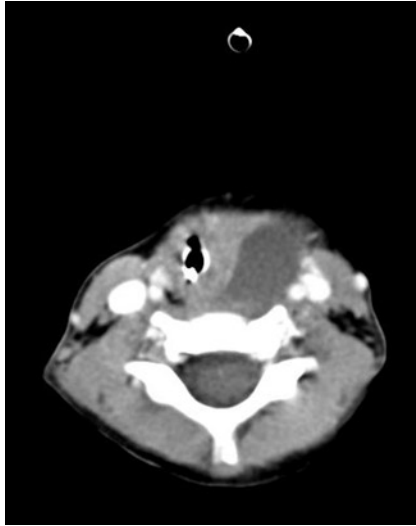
CT scan showing multiloculated lymphatic malformation in the parapharyngeal space extending inferiorly on the left side of the neck. There was airway obstruction and the child presented with snoring.
